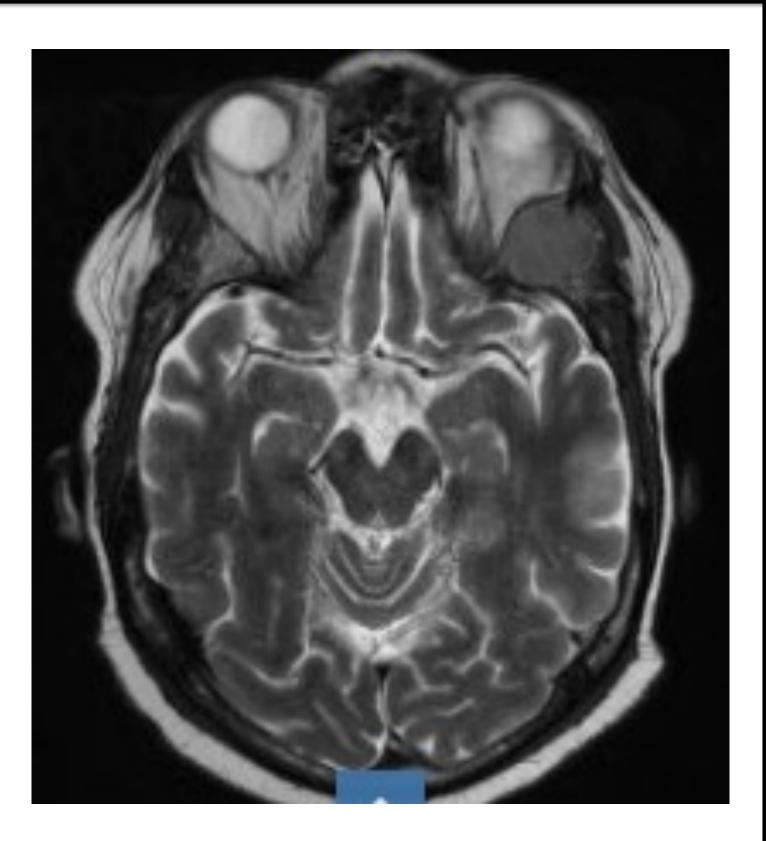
MRI brain/orbits w/wo contrast: Lytic lesions throughout calvarium, skull base, and facial bones with a 3.4 cm x 2.4 cm left orbital wall mass
